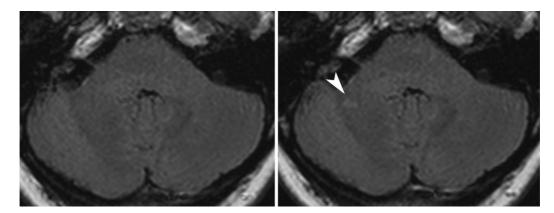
Intraindividual comparison of axial T2-wheighted FLAIR image in a 31-year-old female patient presenting with unilateral optic neuritis. Higher sensitivity in the detection of an inflammatory brain lesion is documented at 3.0 T (image on the right) as compared to 1.5 T (image on the left) with a lesion detected on the 3.0 T but not on the 1.5 T image (arrow head).
